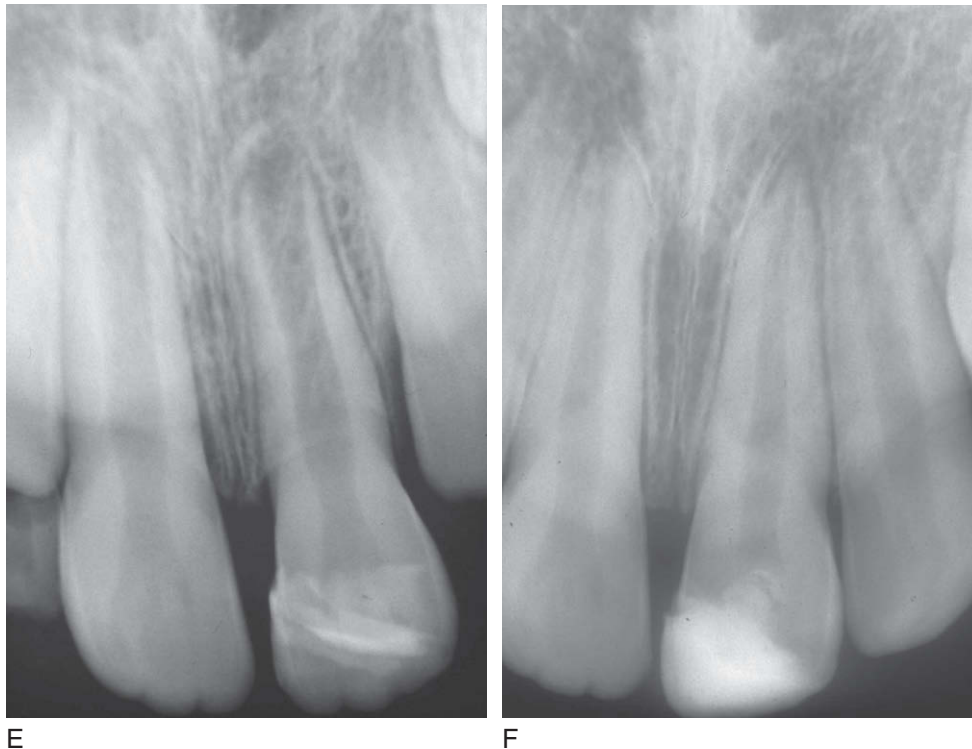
cont'd E, Postoperative radiograph: the patient had a second fall 1 year later and Cvek's technique was performed. F, Radiograph taken 4 years after the first trauma and 2 years after partial pulpotomy; both teeth are vital and the apex of the left central incisor is closed. (Courtesy Dr. Lucia Blanco.)
